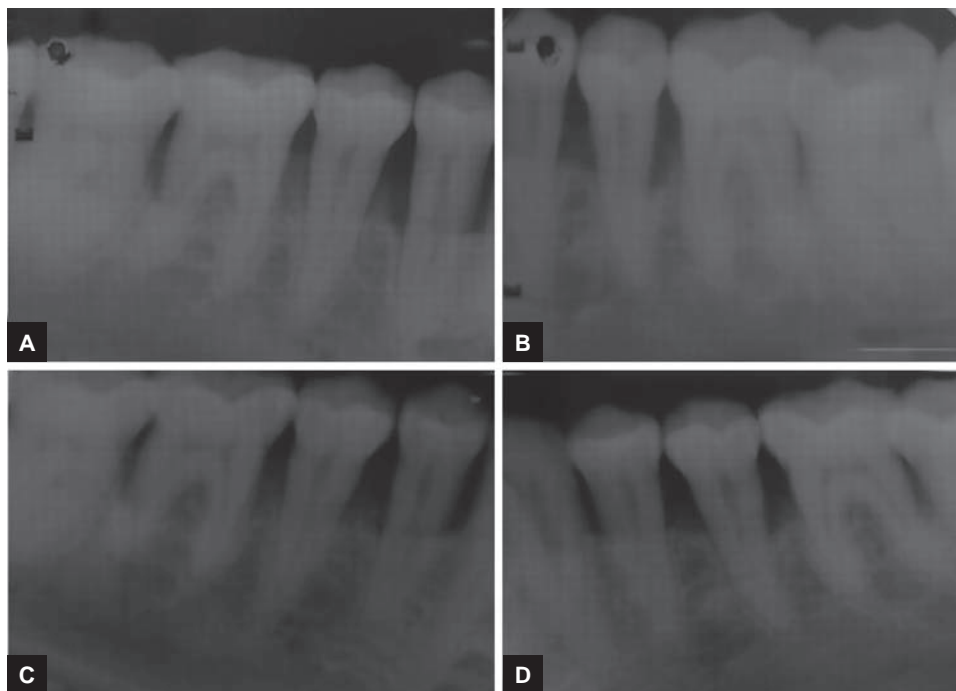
to D: Preoperative and postoperative radiographs of case 2. (A) Preoperative radiograph of test site showing angular defect with mandibular left first molar. (B) Preoperative radiograph of control site showing angular defects with mandibular right first molar. (C) One-year postoperative radiographs of the test site showing bone fill on the distal of the mandibular left first molar. (D) One-year postoperative radiographs of the control site showing bone fill on the mesial of the mandibular right first molar
